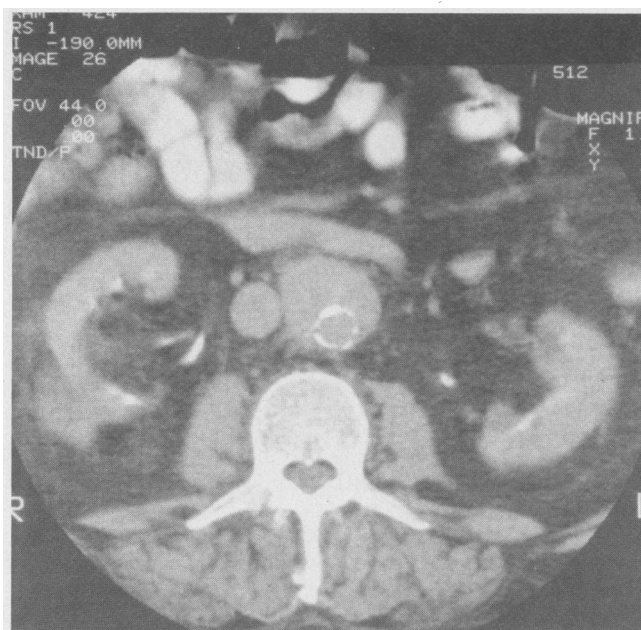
An axial computed tomographic scan of the abdomen shows ring calcification in the intima of the abdominal aorta with surrounding soft tissue density anteriorly. No gas is present in the soft tissue mass nor is there adjacent bone destruction.
